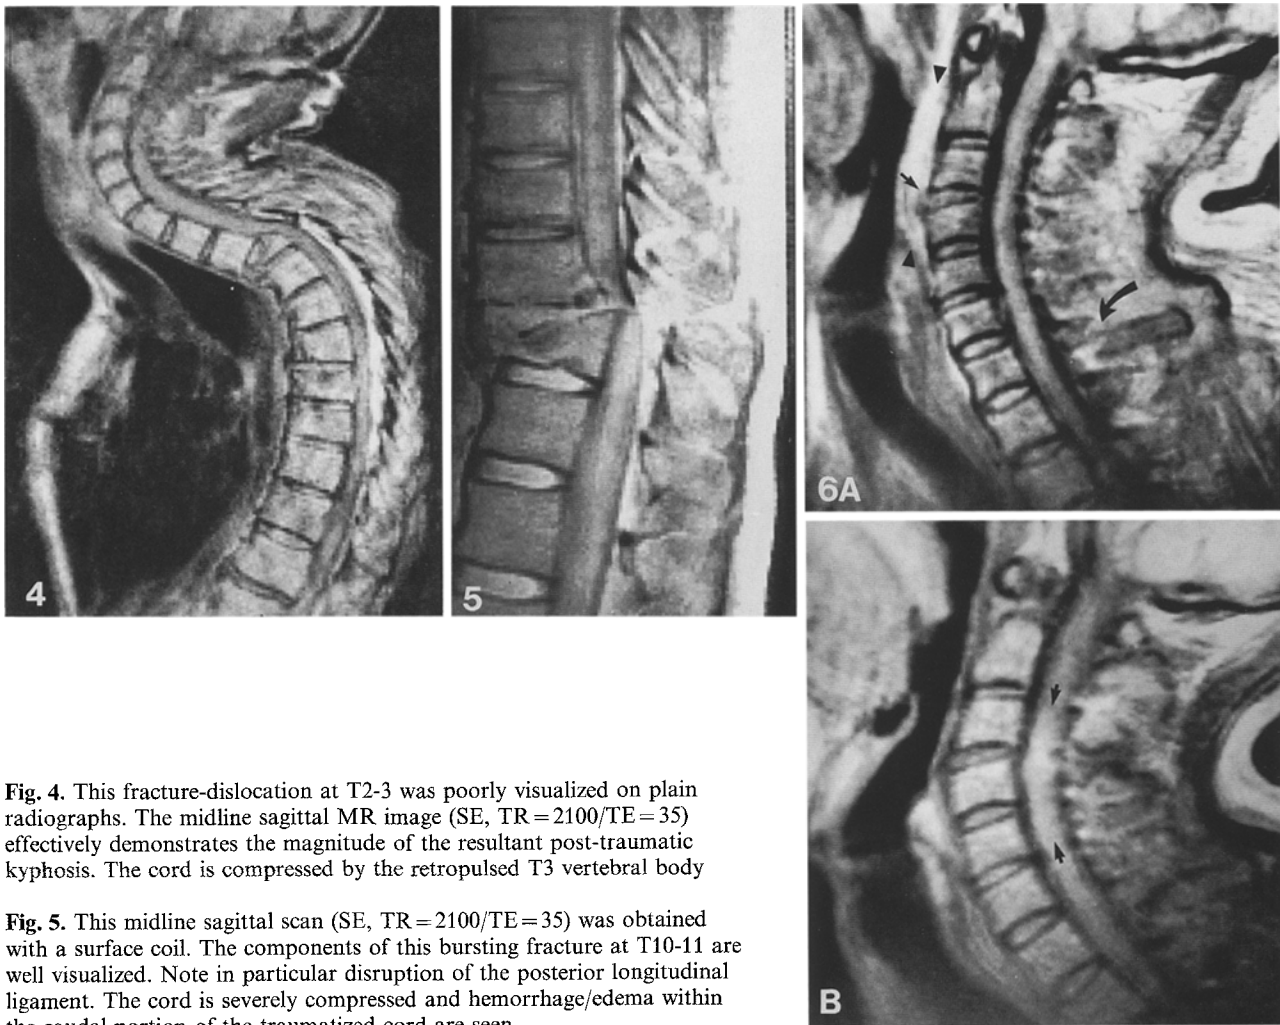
This fracture-dislocation at T2-3 was poorly visualized on plain radiographs. The midline sagittal MR image (SE, TR = 2100/TE = 35) effectively demonstrates the magnitude of the resultant post-traumatic kyphosis. The cord is compressed by the retropulsed T3 vertebral body
